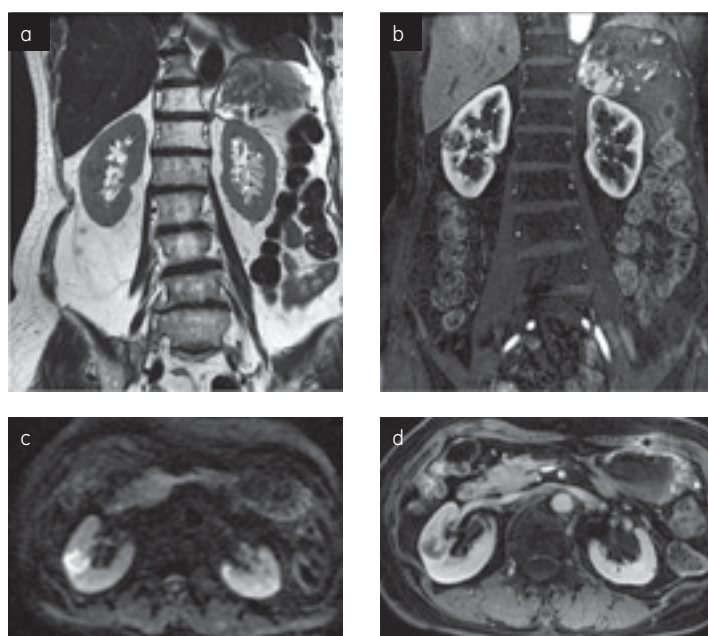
Renal metastasis from rectal cancer. All water images generated with LAVA Flex. (a) Breath-held coronal T2WI. (b) Breath-held Dynamic contrast enhanced water image with Smart prep. (c) Respiratory triggered DWI (b-value 800 s/mm²). (d) Breath-held contrast enhanced water image.
